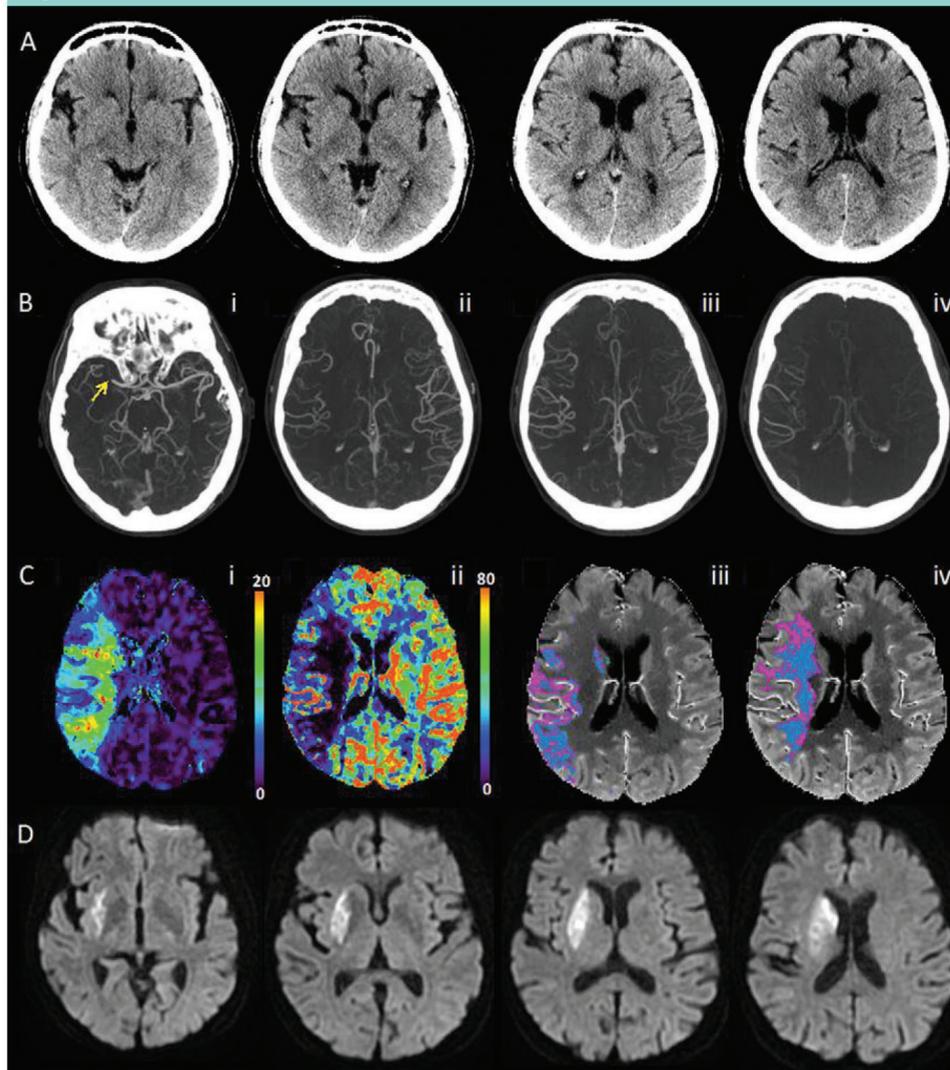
Multimodal CT images obtained 1 hour 28 minutes after symptom onset in a 78-year-old woman with NIHSS of 18 and right hemisphere symptoms. *A*, Unenhanced CT ASPECTS score is 8. *B*, Proximal right M1 MCA occlusion (*i*). Multiphase CT angiography (three phases) maximum intensity projection images (*ii*, *iii*, *iv*) are indicative of one phase delay, with similar extent and prominence when compared with the contralateral side. These suggest a score of 4 and that the patient should undergo treatment. *C*, CT perfusion Tmax and CBF maps (*i*, *ii*). A CBF-defined predicted infarct core is 113 mL (blue) and mismatch ratio (blue/pink areas) (*iii*, *iv*) is 1.7; this indicates the patient should not undergo treatment. Multiphase CT angiography and perfusion CT imaging are incongruent for treatment decision. *D*, MR diffusion images at 26 hours after admission show the final infarct as hyperintense. This M1 MCA clot recanalized with intraarterial therapy.
